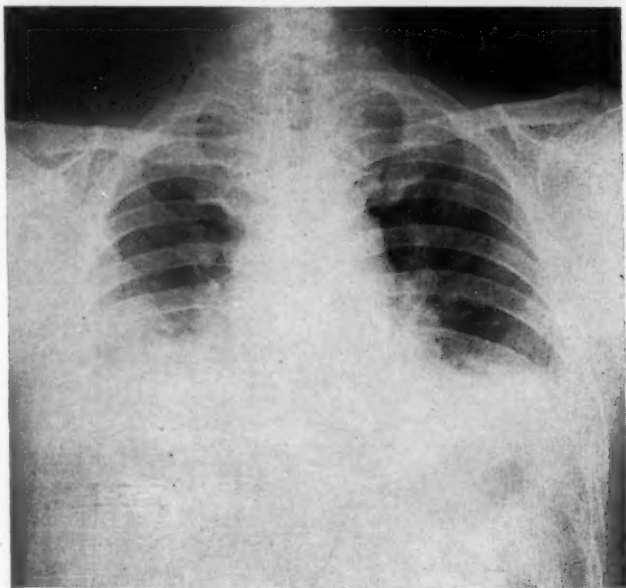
Chest X-ray taken May 13, 1946, three days after removal of foreign body, showing particularly fluid in both pleural cavities.
